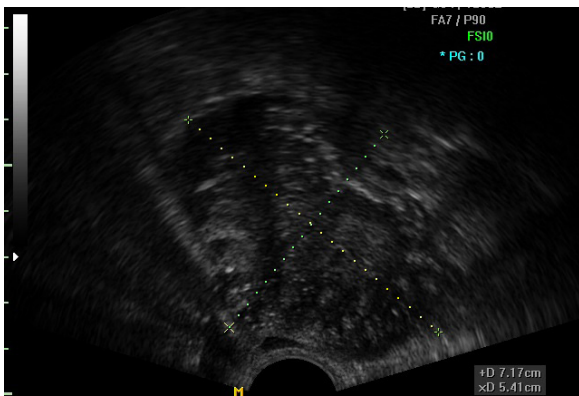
Transvaginal ultrasound image of a purely solid benign Brenner tumor with multiple scattered calcifications and acoustic shadowing behind the tumor
